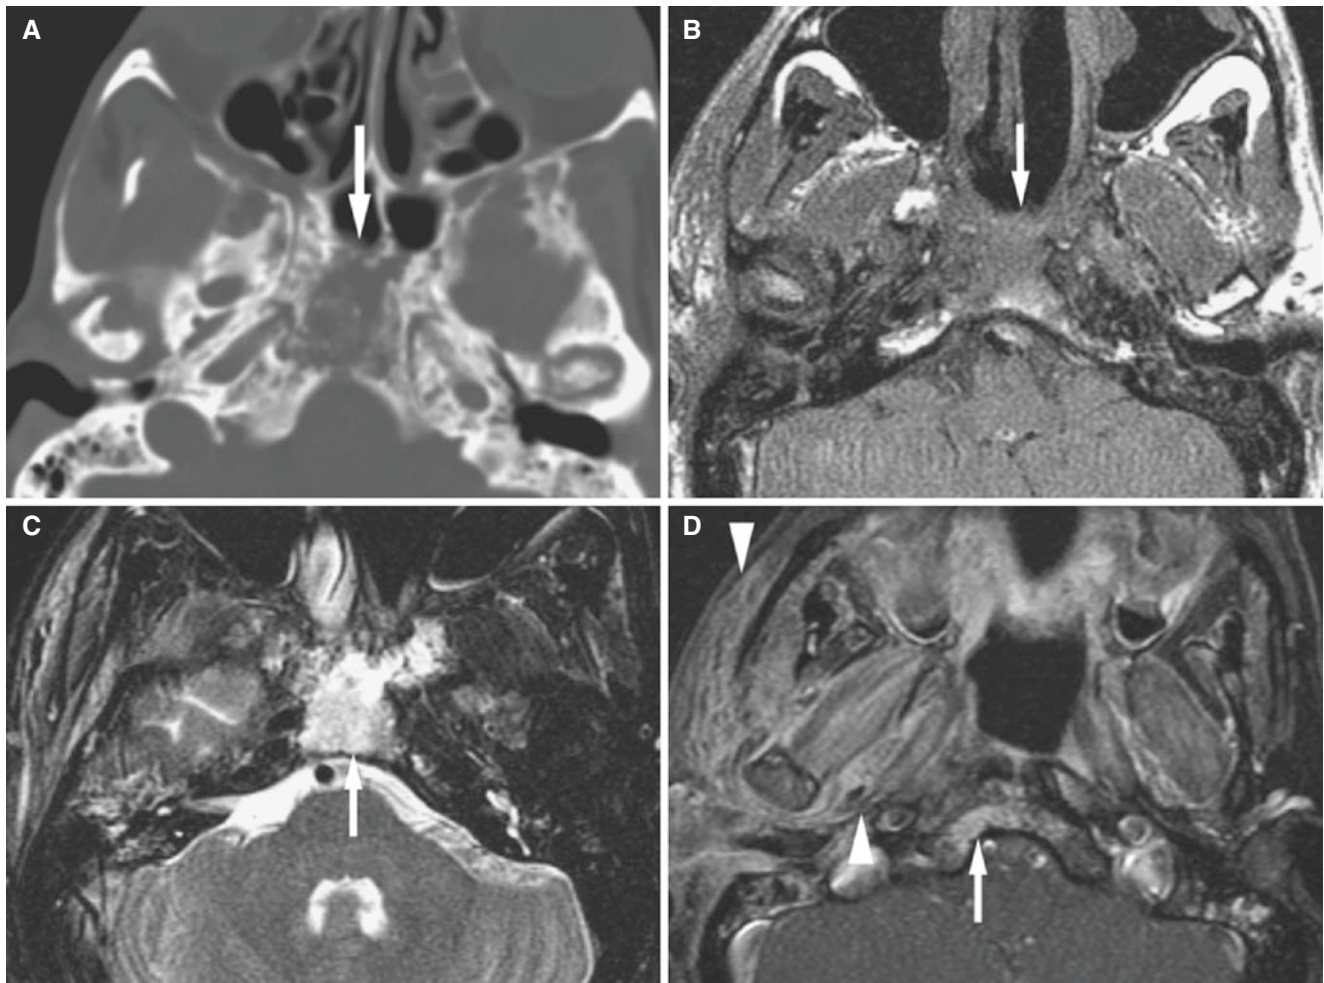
Osteoradionecrosis; 42-year-old male status post radiation treatment for nasopharyngeal cancer. (A) Axial CT image shows lytic and osteosclerotic changes of the skull base bone (arrow). (B) Axial T1-weighted MRI shows hypointense lesion (arrow). (C) Axial
